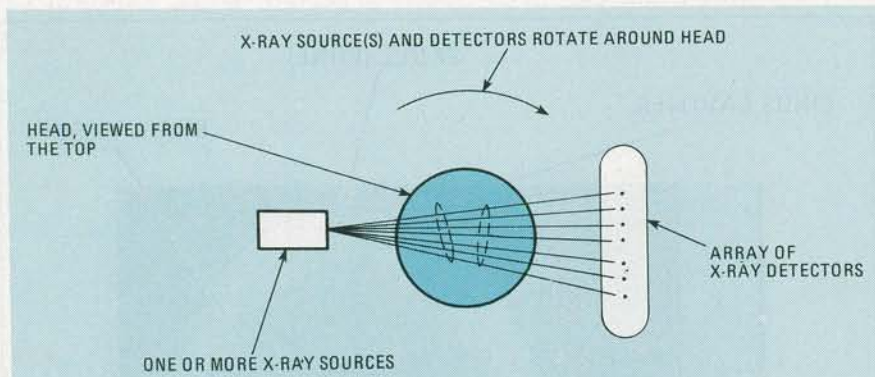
SET UP USED in computerized axial tomography. Here, one or more X-ray sources rotate around the part of the body being scanned.
